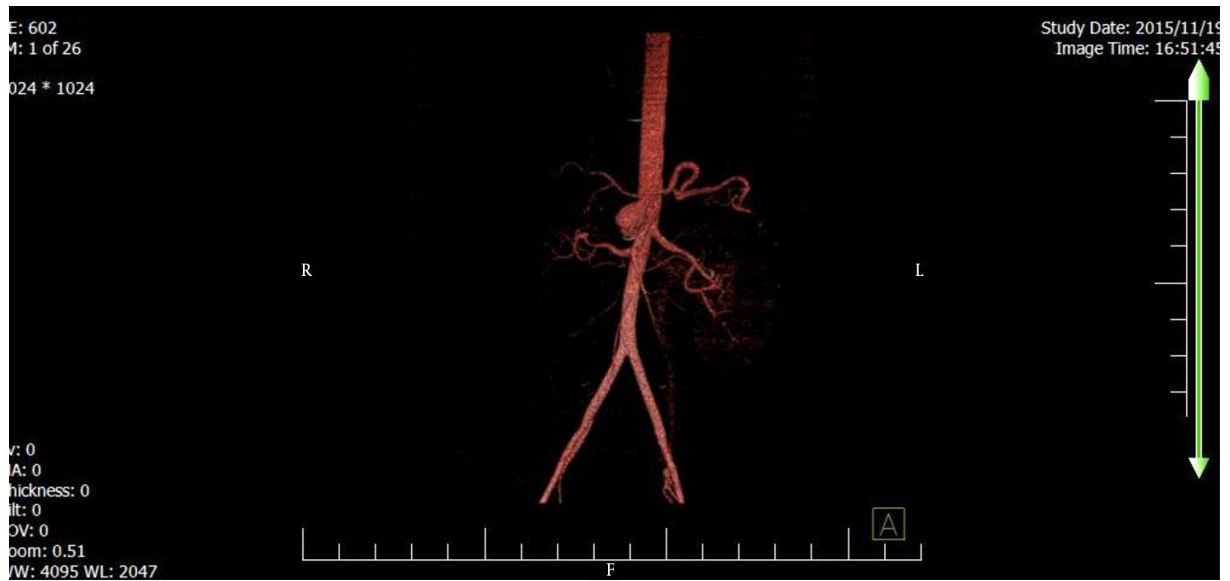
CT Angiography Image Obtained from 44-Years Old Women with a Splenic Artery Aneurysm
